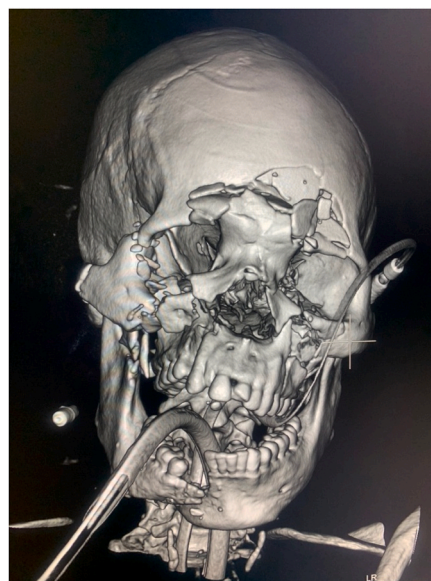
CT Facial views 3D reconstruction*.
